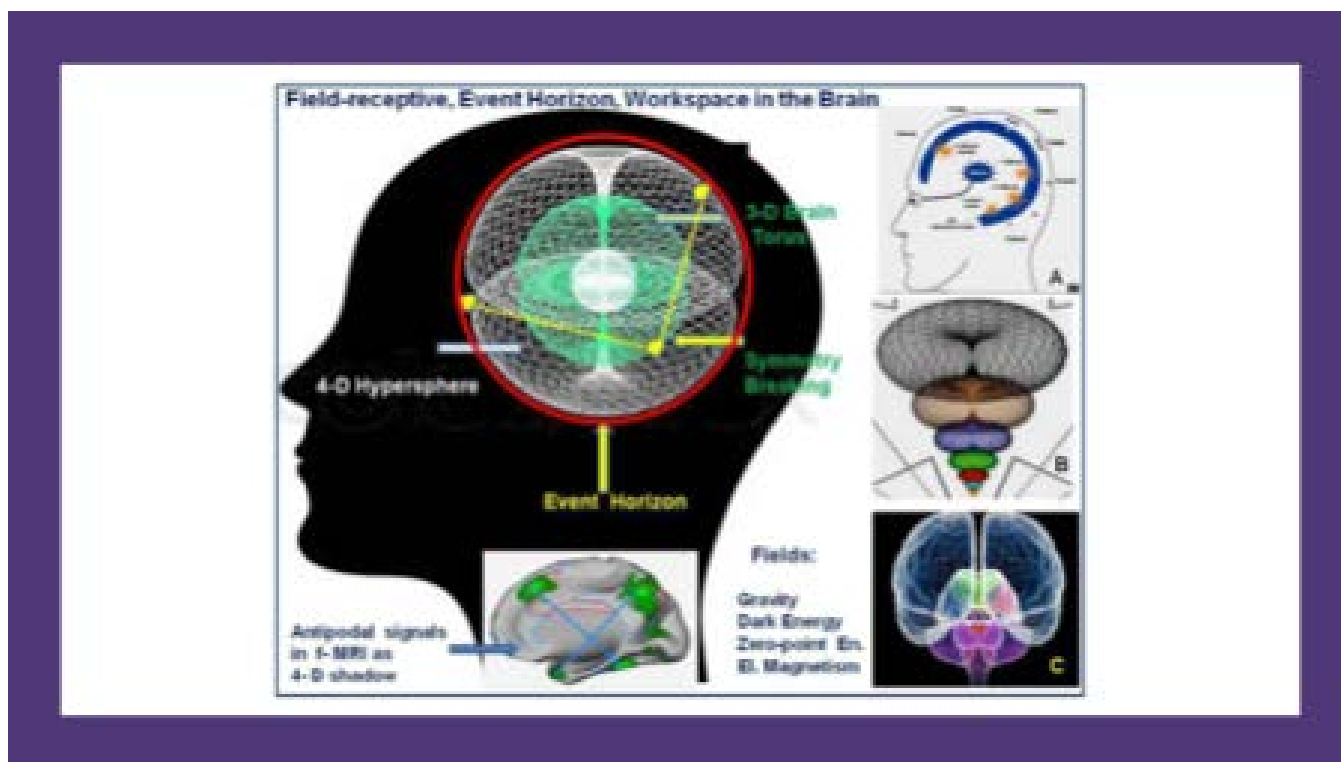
Field receptive, event horizon model of consciousness, depicted in various representations: Main picture: postulated double-toroidal field integrating the 4D-hypersphere workspace with the event horizon surface, projecting the integral individual information as an internal model of the self. Note that the 4-D hypersphere is pictured within the skull, but that it can exhibit an extended localization, surrounding the brain or even the whole organism, due to fractal properties and can also be positioned at a micro-scale at or within the brain cells or extracellular space. Embedding of the 3-D toroidal domain of the brain within a 4-D hypersphere is therefore multidimensional and fractal at various levels of organization. Symmetry breaking occurs from the 4-D hypersphere to the 3-D internal brain torus, of which the traces can be detected by series of f-MRI scans of the brain as antipodal activity domains in the brain tissue (inset middle below). Insets at the right A: Supposed broadcasting centres in brain that may explain binding and global synchrony, according to Baars B: Fractal organization of information scales in the extended brain. C: Hemi-spherical anatomy of the brain resembling a toroidal geometry.
